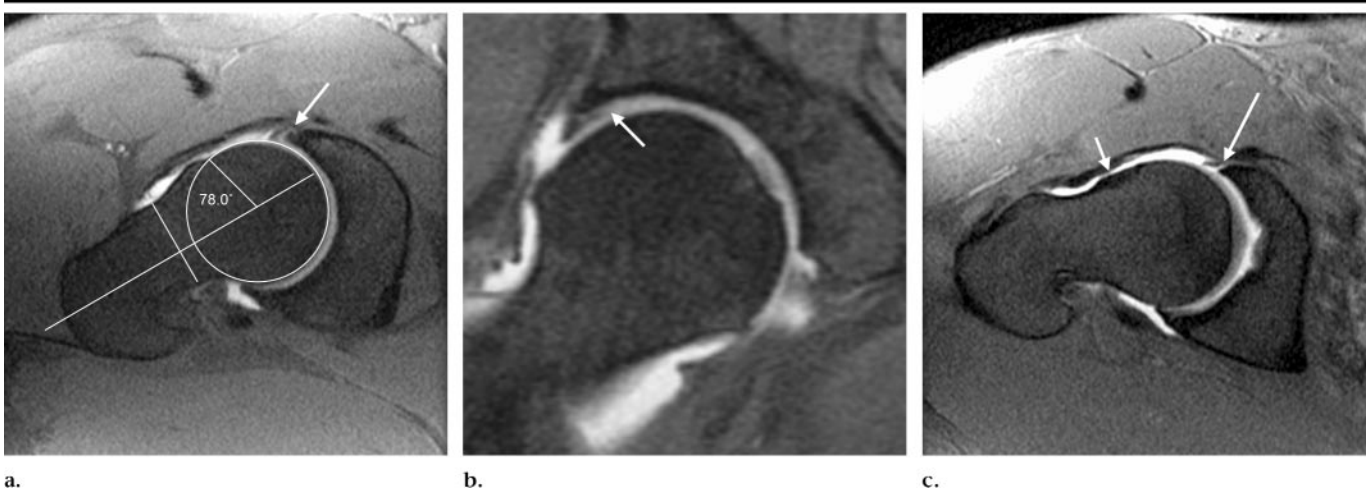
(a) Oblique sagittal fat-saturated T1-weighted MR arthrographic image (550/10) shows abnormal contour of the femoral head-neck junction in a 31-year-old man with femoroacetabular impingement. The α angle measured 78° . There is an anterosuperior labral tear (arrow). (b) Sagittal T1-weighted MR arthrographic image (520/10) shows anterosuperior cartilage fissure with a delaminating component (arrow) in a different patient. (c) Oblique sagittal fat-saturated T1-weighted MR arthrographic image (600/8) shows abnormal anterior femoral head-neck offset (short arrow) and anterosuperior labral tear (long arrow) in yet a third patient.
